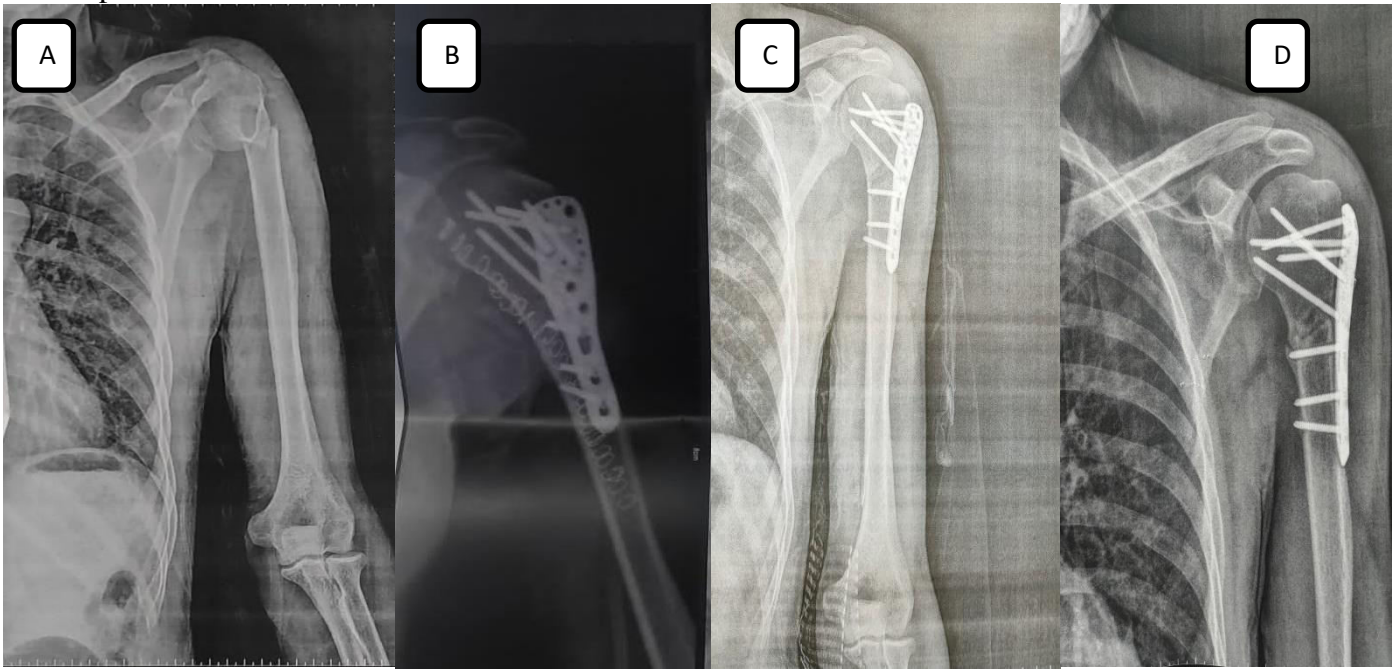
A: plain x-ray at time of trauma, B: immediate postoperative x-ray, C: follow up 1 months, D: follow up 6 months for a case treated under general anaesthesia open reduction and internal fixation by PHILOS were done.
